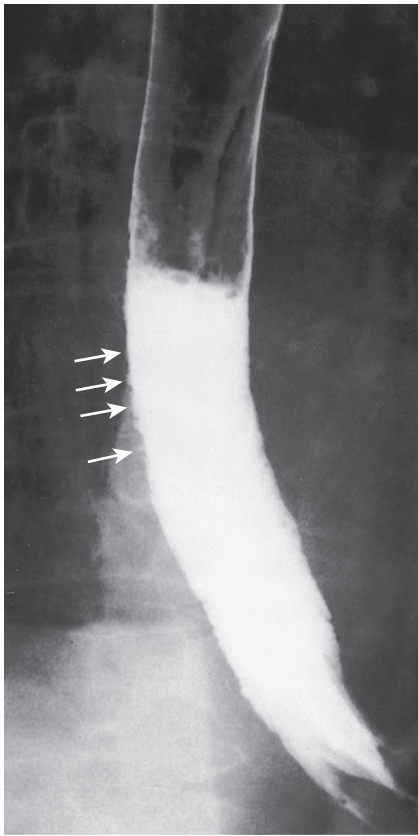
Alendronate-induced esophagitis. Multiple tiny ulcers (arrows) are seen in profile in the distal esophagus. This patient was taking alendronate (Fosamax) for the treatment of postmenopausal osteoporosis. (Courtesy Barbara Sabinsky, MD, Stamford, CT.)
